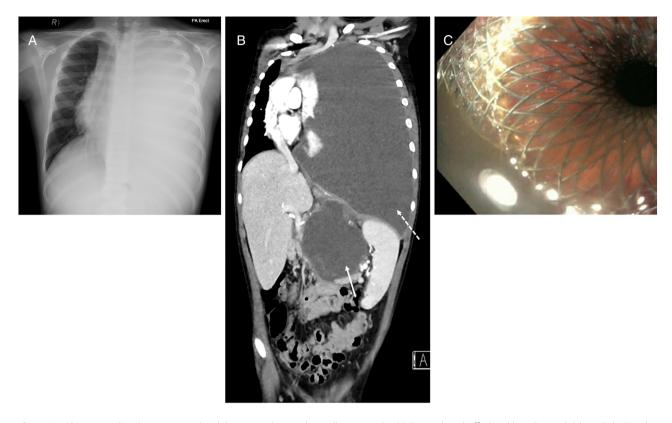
Chest X-ray (CXR) on presentation (A), pancreatic pseudocyst (long arrow) with large pleural effusion (dotted arrow) (B), and deployed cyst-gastrostomy stent (C).
